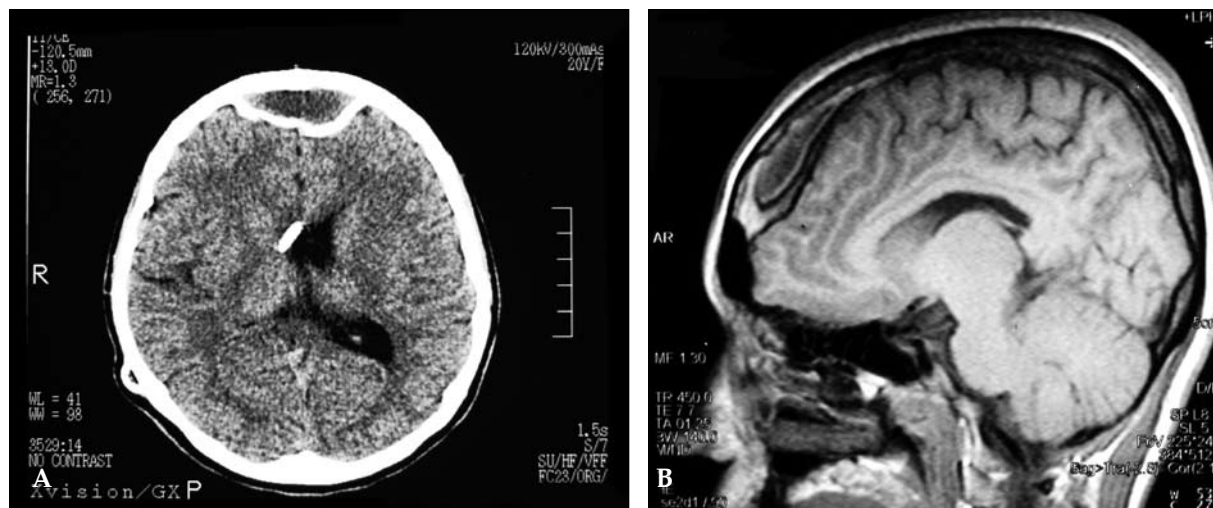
Axial CT section (A), and T1-weighted sagittal MRI section (B) showing bifrontal chronic calcifying epidural hematoma.
